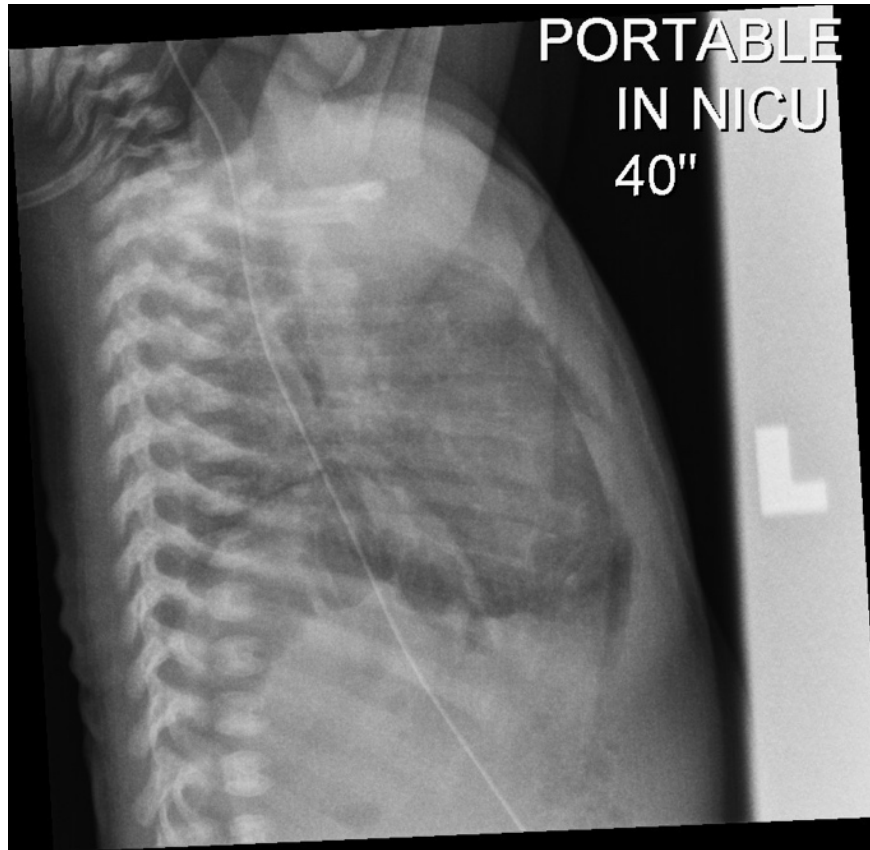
AP and lateral chest X-ray on day 12 of life following new onset tachypnea and tachycardia shows bilateral hazy opacities in the lower lung fields with an elevated left hemidiaphragm. A lucency is noted on the left side at the cardiac margin. Lateral X-ray shows that the lucency is bowel lying below the left diaphragm. The right lower zone opacity is either elevated right hemidiaphragm or atelectasis. The location and shape of the opacities are suggestive of diaphragmatic eventration, with abdominal contents herniating into the thorax on the left, still under the diaphragm.
